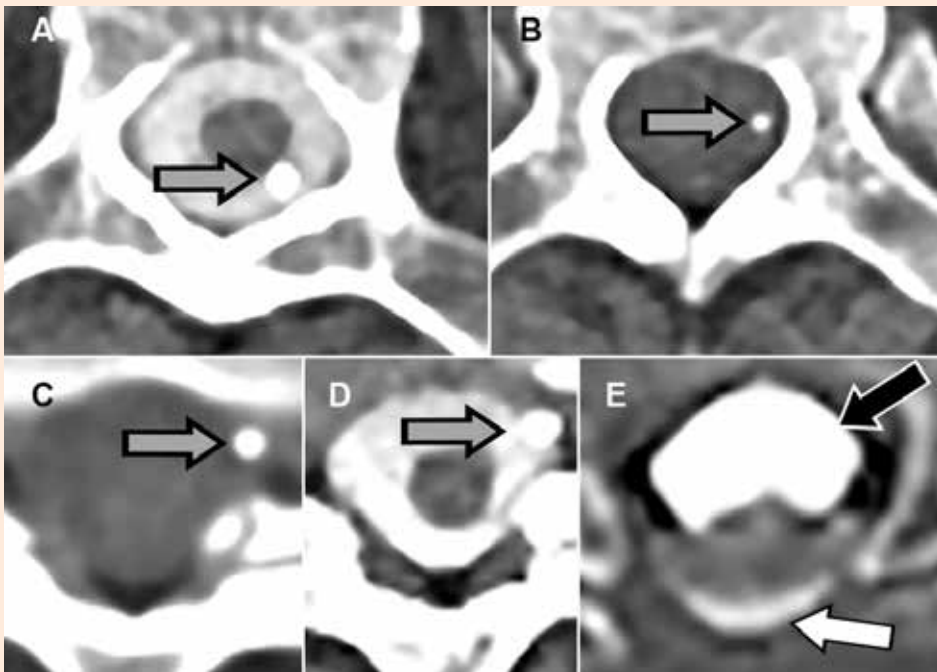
CAP-CT MPR myelography revealed a normal intrathecal 8731SC catheter tip position (A, gray arrow) and a regular small-diameter Ascenda catheter tip position (B, gray arrow). The NCCT MPR image fostered suspicion of an epidural tip position of the 8731SC catheter (C, gray arrow). LP CT myelography confirmed the epidural position (D, gray arrow). CAP-CT MPR myelography showed extensive subdural (E, black arrow) and minimal intrathecal (E, white arrow) contrast material, which explained the irregular contrast material distribution found with CAP myelography (Fig.3C).
